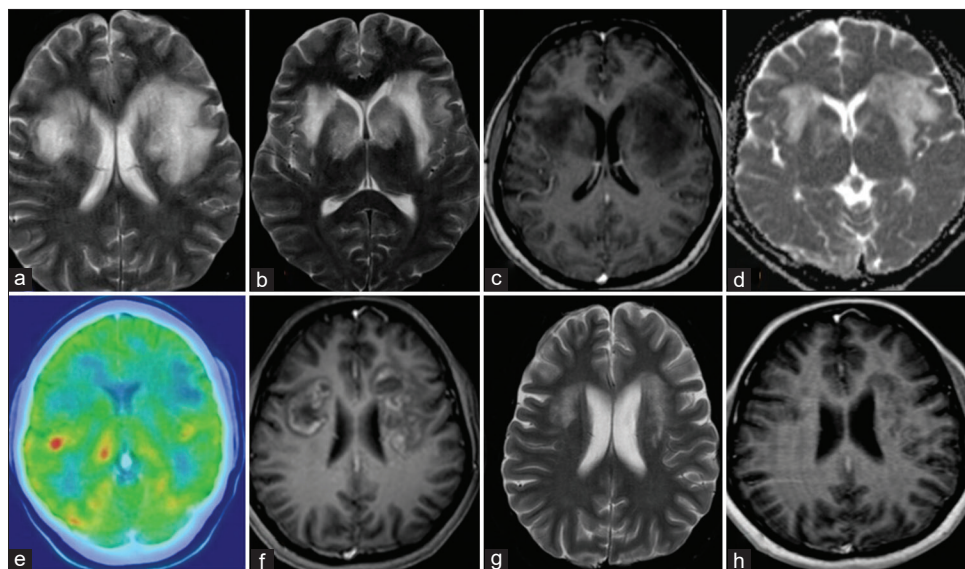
A 45-year-old female with immune mediate disease. Baseline axial T2W MRI (a and b) shows T2W hyperintense lesion involving bilateral corona radiata in a symmetrical distribution. There is no contrast enhancement (c) or low signal on ADC (d). PET-CT imaging does not show increased activity in the areas of interest (e). Subsequent follow-up MRI brain done 3 months later shows new development of peripheral incomplete rim-like areas of enhancement (f). Steroid therapy was continued and there was significant disease regression followed by the disappearance of enhancement, another 6 months later (g and h). ADC: Apparent diffusion coefficient, PET-CT: Positron emission tomography-computed tomography.
